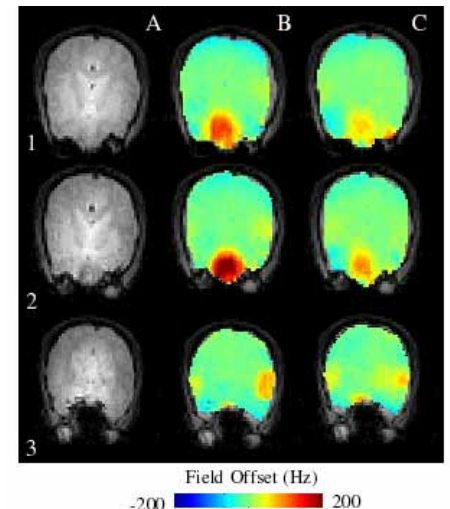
A) FLASH MRI images of axial slices (1-3), magnetic field maps after B) RT shim optimization, and C) RT and passive shim optimization
